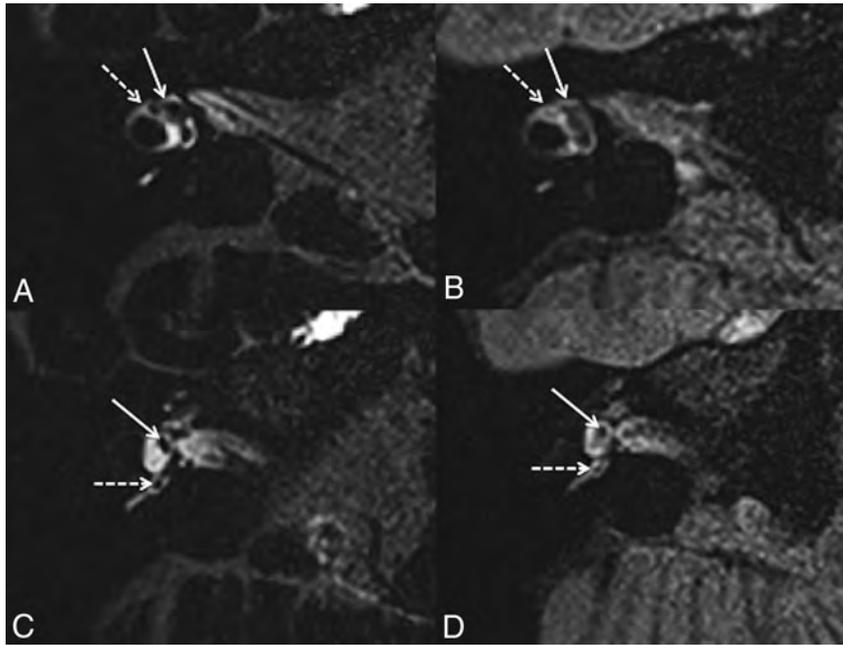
A 42-year-old woman with right possible MD. Axial 3D-FLAIR CFA at the level of the lateral semicircular canal (A) shows a normal utricle (white arrow) and lateral ampulla (right dotted arrow). C, Axial 3D-FLAIR CFA through the inferior part of the vestibule shows a normal saccule (white arrow) and posterior ampulla (white dotted arrow). Axial 3D-FLAIR heavily-T2 VFA at the level of the lateral semicircular canal (B) shows a normal utricle (white arrow), while the lateral ampulla (right dotted arrow) is barely visible. D, Axial 3D-FLAIR heavily-T2 VFA through the inferior part of the vestibule shows a normal saccule (white arrow) and posterior ampulla (white dotted arrow).
